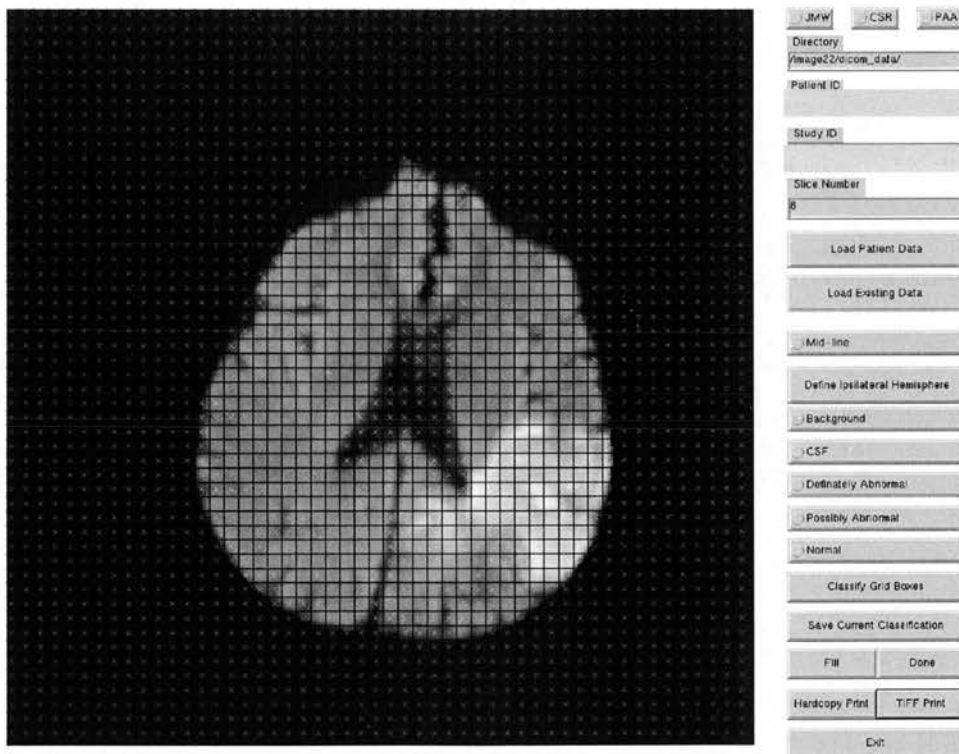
The SGAT grid analysis program user interface (Patient A, left hemisphere ischaemic lesion on DWI at 4 hours after stroke onset). Each grid box is 4.69×4.69 mm.
